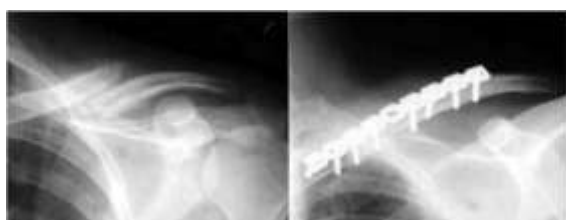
Radiograph showing a) a midshaft fracture (Pre-OP) b) After surgical management (Post-OP)
